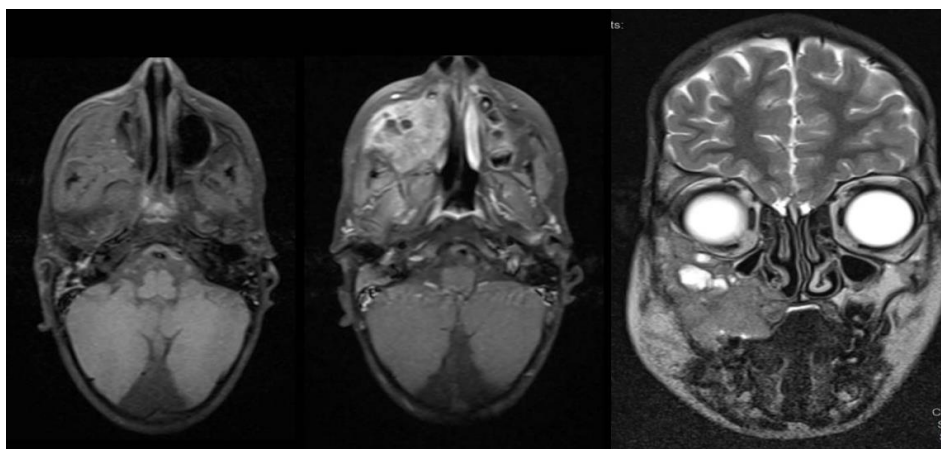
Brain MRI of child showing axial T1, T1 with Gadolinium, and coronal T2 sections demonstrating a tumoral process centered on the right maxillary sinus with local extension
